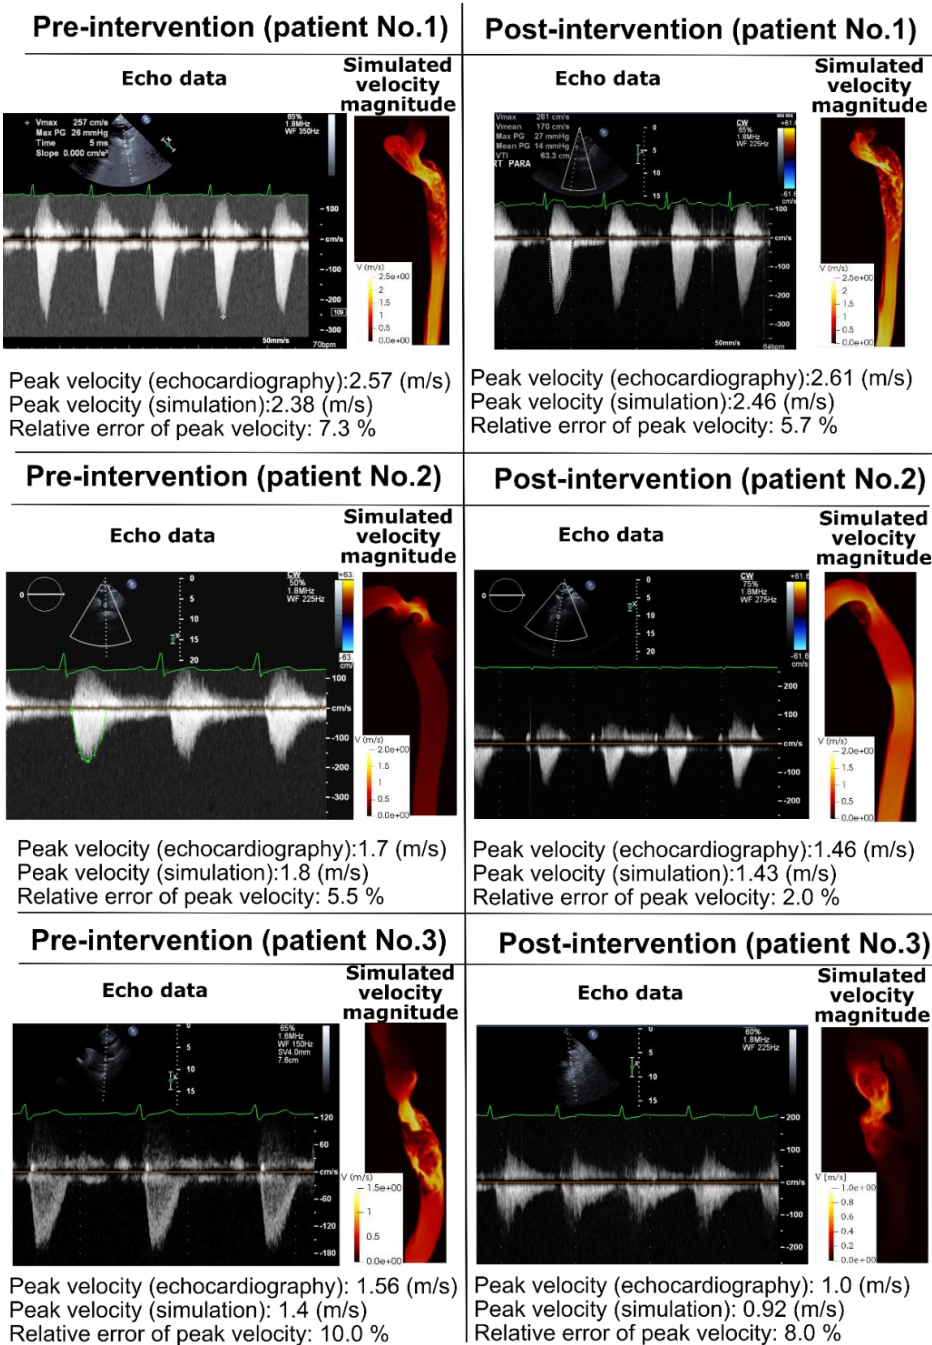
Validation against Doppler echocardiography. Doppler echocardiography data and results of the computational framework (based on LPM and LBM) in Patients No. 1 to 3 in pre and post intervention states.
